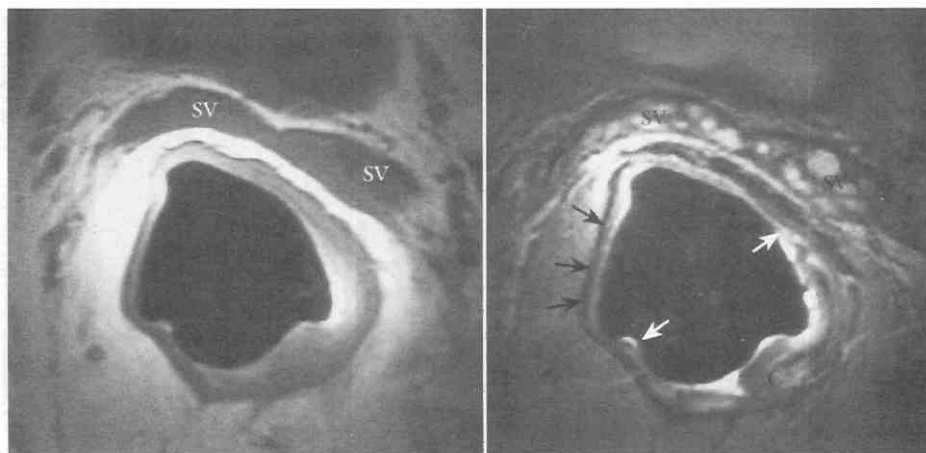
Endorectal coil imaging of superficial rectal tumor. *A*, Axial T1-weighted, spin-echo image (TR = 500 msec, TE = 14 msec) shows posterolateral rectal wall thickening. *B*, Axial fast spin-echo image (TR = 3800, TE_{eff} = 133 msec) shows the mucosal tumor (*C*). *Black arrows* indicate the low-signal-intensity rectal muscularis propria. Normal mucosa (*white arrows*) appears as a thin intermediate-signal-intensity stripe. SV, seminal vesicles; TE_{eff}, effective echo time.
